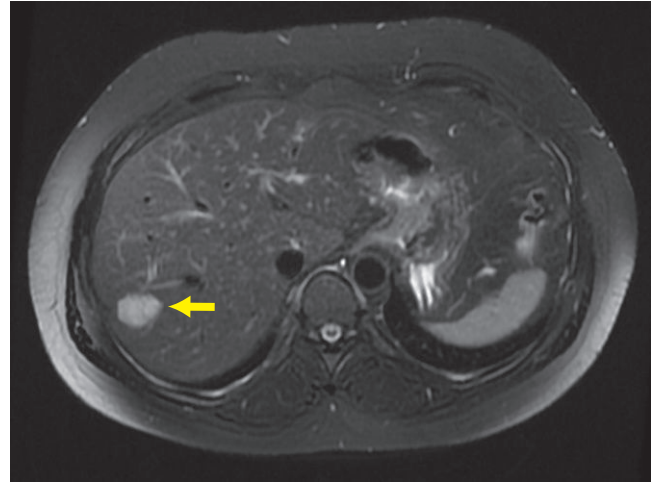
Heavy T2-weighted MRI shows increased signal intensity (arrow), which is a typical feature of a cavernous hemangioma.
